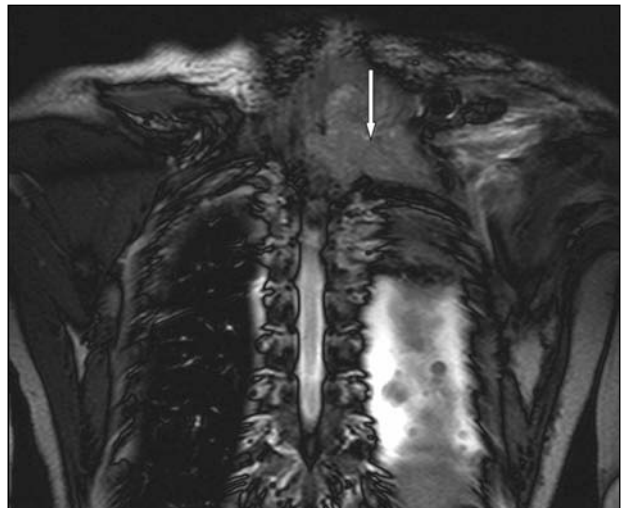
This T2 Coronal MR image visualizes a large, inhomogeneous, destructive mass in the region of the left lung apex (see arrow).
